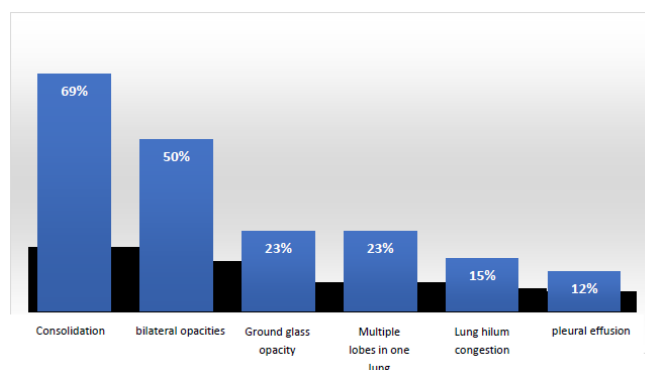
Sample distribution according to radiological findings on the CT scan.
